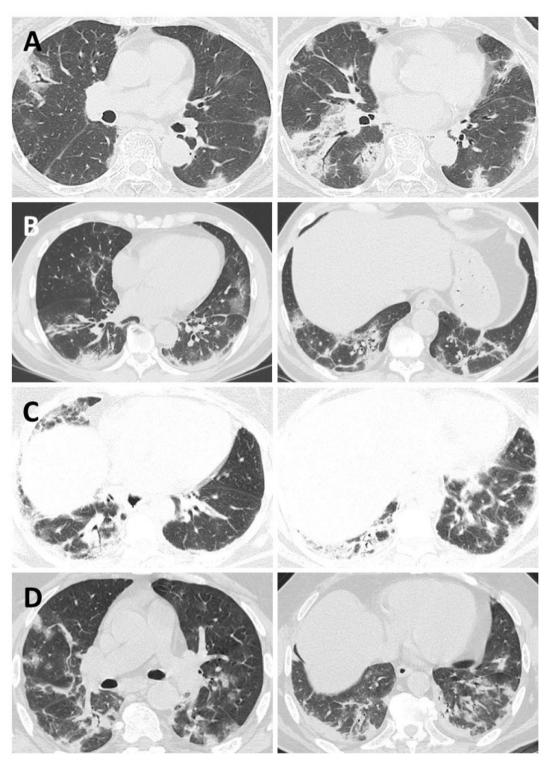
Similarities in CT scans findings of two patients with anti-MDA5 dermatomyositis (A*, C) and two patients with COVID-19 (B, D). The images show bilateral subpleural areas of patchy ground glass opacities and consolidation accompanied by traction bronchiectasis and perilobular linear opacities.
